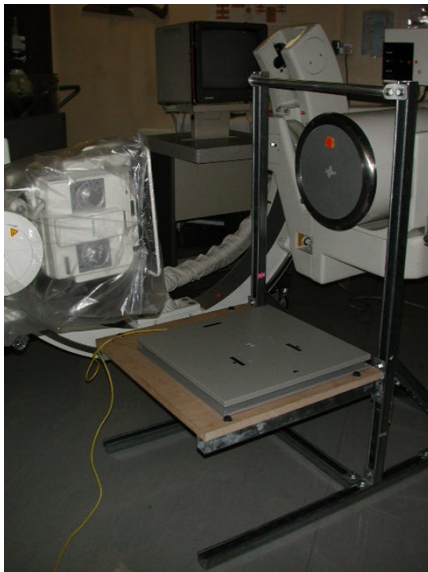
A typical fluoroscopic setup; the subjects knee joint is raised on a fixed platform such that the centre of the knee remains in the in the centre of the Image Intensifier beam. Knee movements are then screened and recorded by the X-ray beam (⁶).
